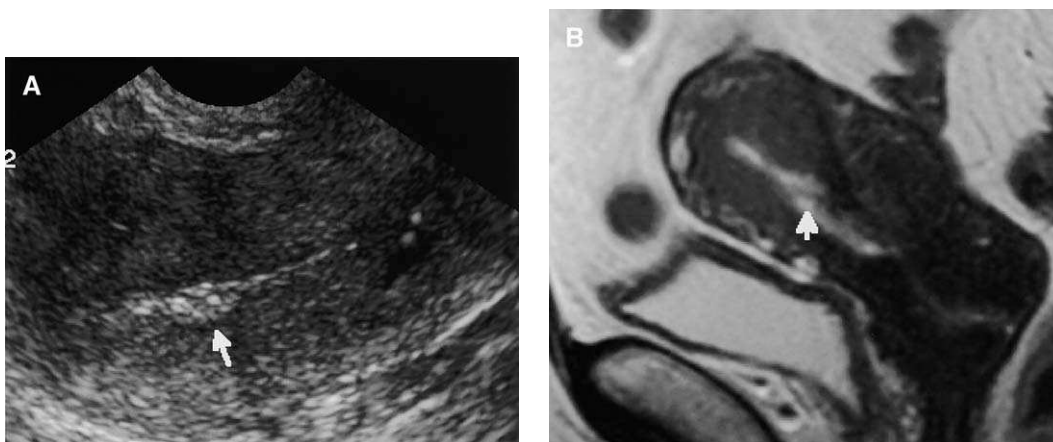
(A) Sagittal SHG in a 42-year-old woman with secondary infertility demonstrates a nondistensible cavity and irregular endometrial lining with an echogenic, nonshadowing focus in the body of the uterus (arrow). (B) Sagittal T2-weighted MRI reveals presence of hypointense linear adhesion within the T2 bright endometrium in the same location (arrow).
